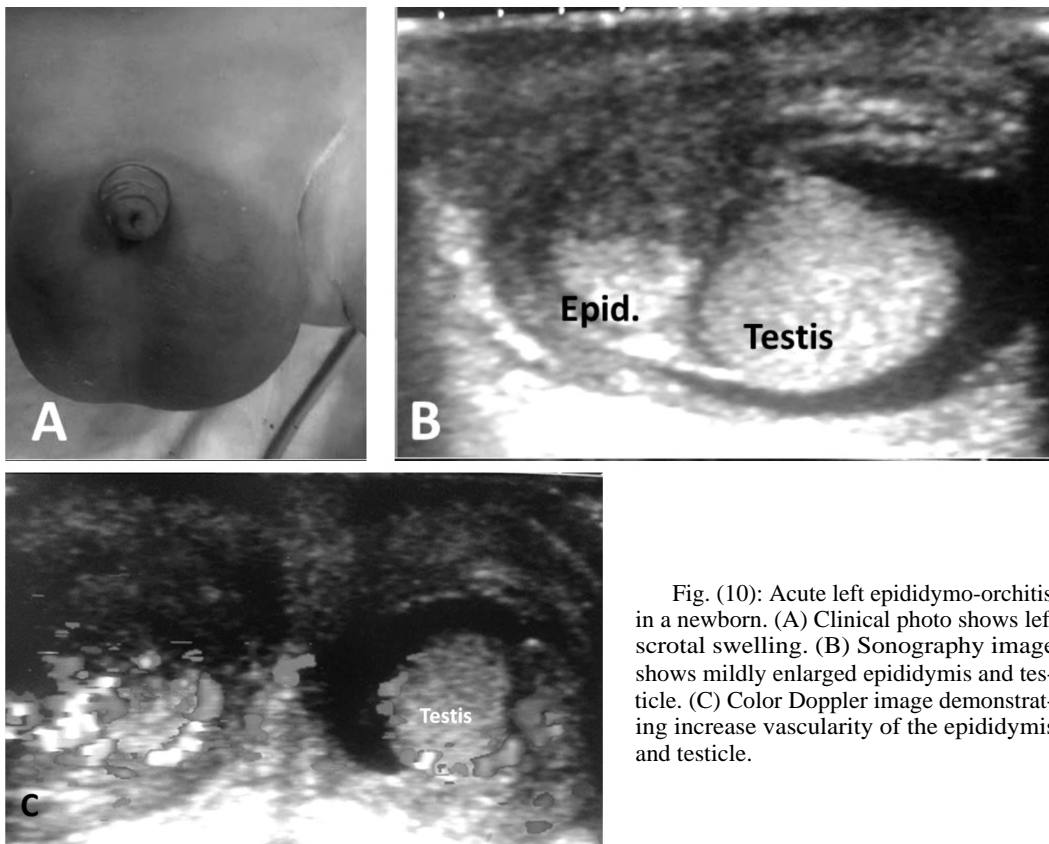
Acute left epididymo-orchitis in a newborn. (A) Clinical photo shows left scrotal swelling. (B) Sonography image shows mildly enlarged epididymis and testicle. (C) Color Doppler image demonstrating increase vascularity of the epididymis and testicle.
